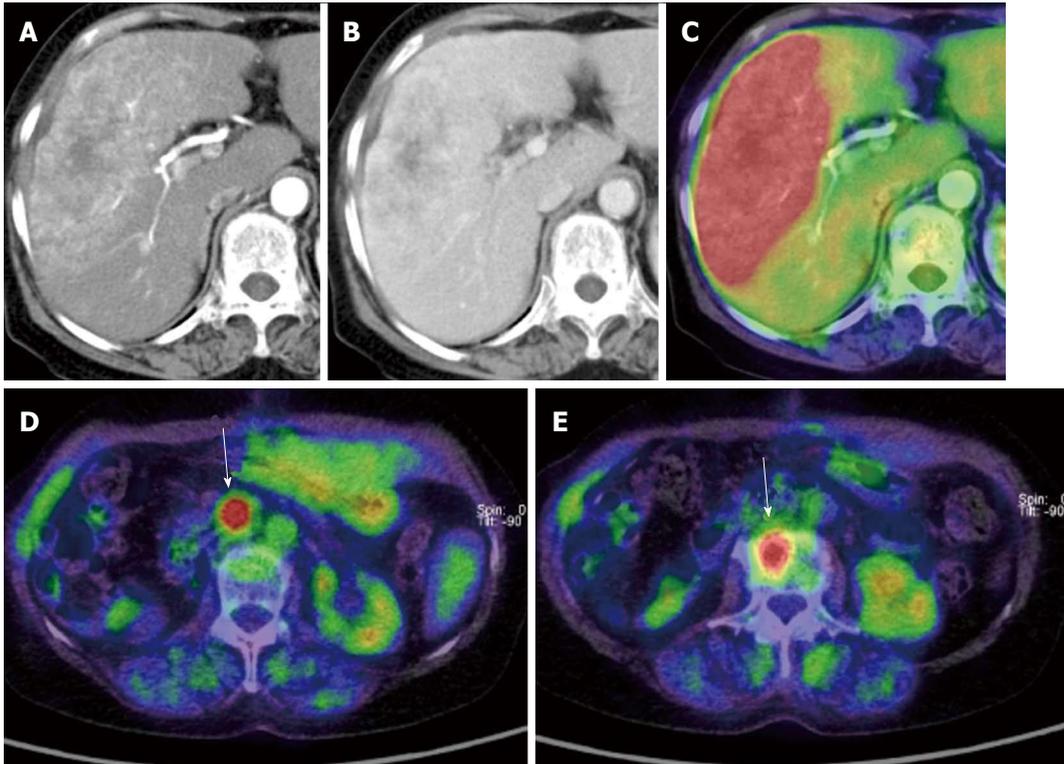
A case of mixed-type hepatocellular carcinoma with extrahepatic metastases. A: Arterial phase of dynamic computed tomography (CT); B: Portal phase of dynamic CT. The tumor shows early enhancement which is a feature of hepatocellular carcinoma (HCC), although it also has a lobular border and delayed enhancement which are features of cholangiocellular carcinoma. Pathological diagnosis was mixed-type HCC; C: This type of HCC shows strong accumulation; D, E: This case also has lymph node and bone metastases (arrows).
